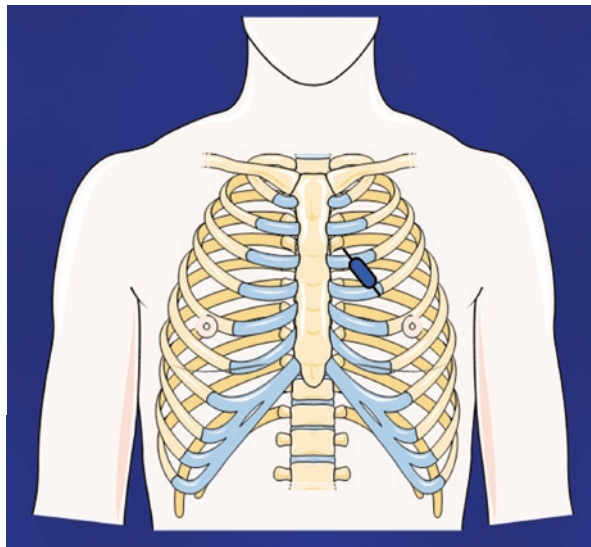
The parasternal long axis (PLAX) view is obtained by placing the transducer in the third to fourth left intercostal space close to the sternum with the beam oriented toward the patient's right shoulder. This orientation slices through the heart on a long axis from base to apex
